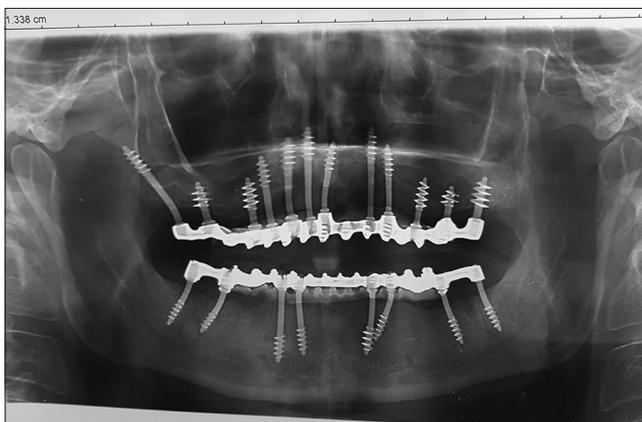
Postoperative panoramic radiograph showing typical distribution of the Strategic Implants® in both jaws. All implants were placed according to the IF methods defined by the International Implant Foundation
